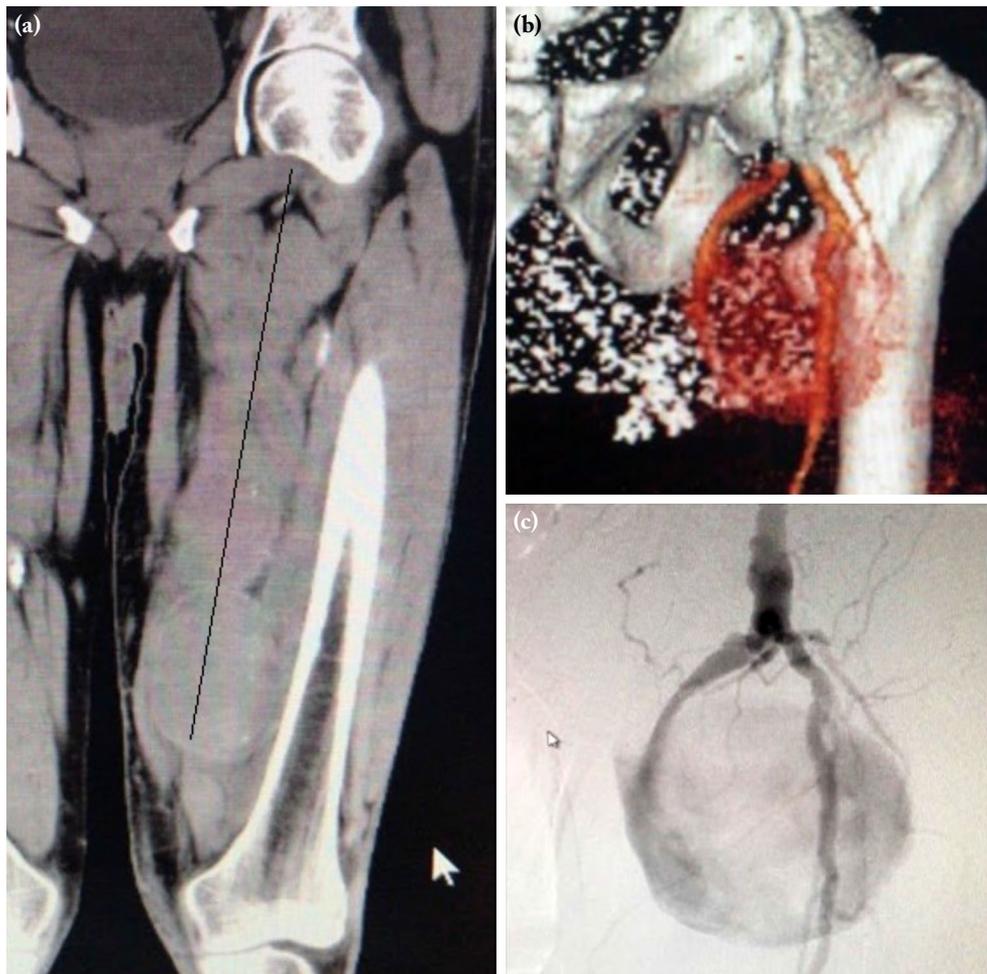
Radiologic imaging of the giant pseudoaneurysm is the source of arterial flow with its capsule and continues from the femoral artery to the popliteal artery. (a) The computed tomography angiography (coronal view); (c) Angiographic image; (c) digital subtraction angiography (DSA) image.
